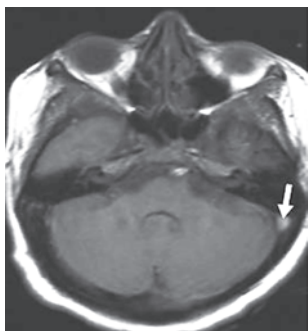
Sigmoid sinus thrombosis. Axial FLAIR MR image showing hyperintense signal at left sigmoid sinus
